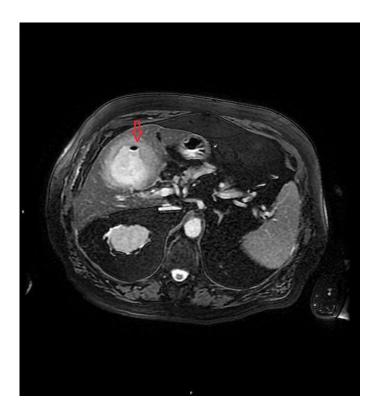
MR image (T2-weighted, axial) demonstrating marked thickening of the gallbladder wall and debris in the gallbladder (red arrow).
